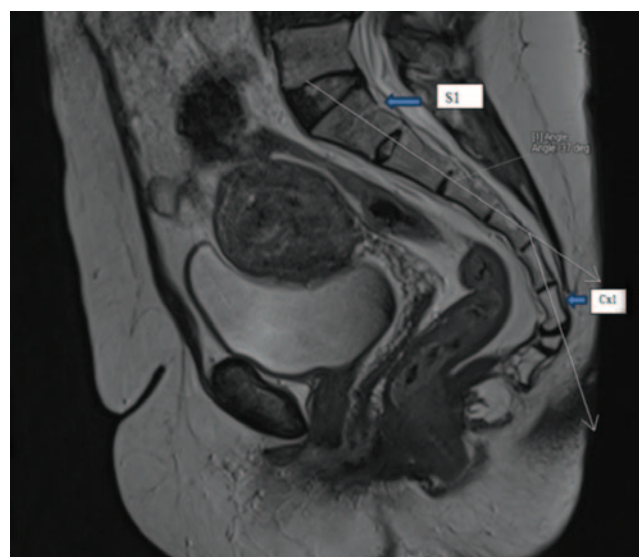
T1-weighted sagittal MRI section. The sacrococcygeal angle was measured as the angle between a line through the middle of the upper and lower endplates of S1 and another line through the middle of the upper and lower endplates of the first coccygeal vertebra. The first sacral (S1) and first coccygeal vertebra (Cx1) are indicated by blue arrows.
